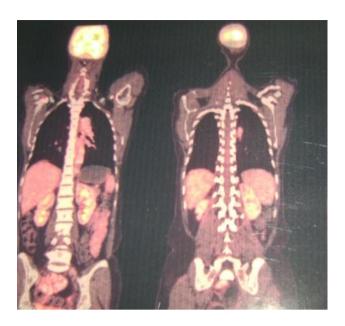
PET scan of no abnormal FDG uptake.
